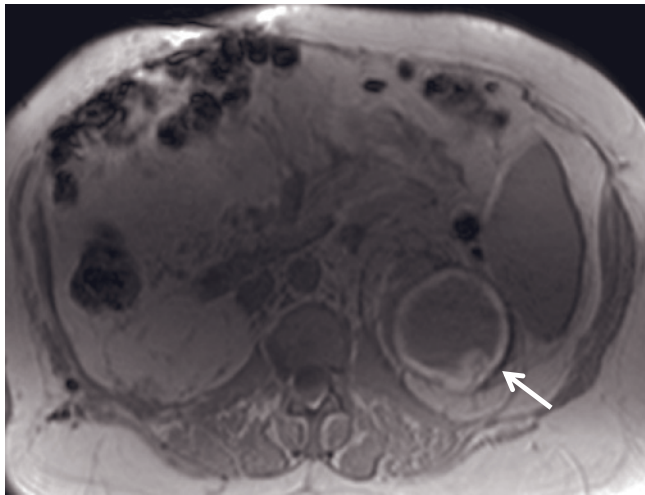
Perirenal hematoma after biopsy. T1-weighted precontrast fat-suppressed SE (a) and immediate postgadolinium SGE (b) images in 1 patient and the same sequences (c, d), respectively, in a second patient. On the precontrast images (a, c) high-signal-intensity fluid is present in the perirenal space of the left kidney, consistent with subacute blood. On the immediate postgadolinium images (b, d), the fluid appears low in signal intensity because of rescaling of the tissue signal intensities after gadolinium administration. T2-weighted SS-ETSE (e) T1-weighted precontrast (f), and postgadolinium (g) fat-suppressed SGE images in a third patient. There is heterogeneous-signal-intensity fluid in the left perinephric space on T2 (e)- and T1 (f)-weighted images, displacing the kidney anterior and laterally, consistent with a perirenal hematoma, after renal biopsy. Note also a thick-walled cyst within
